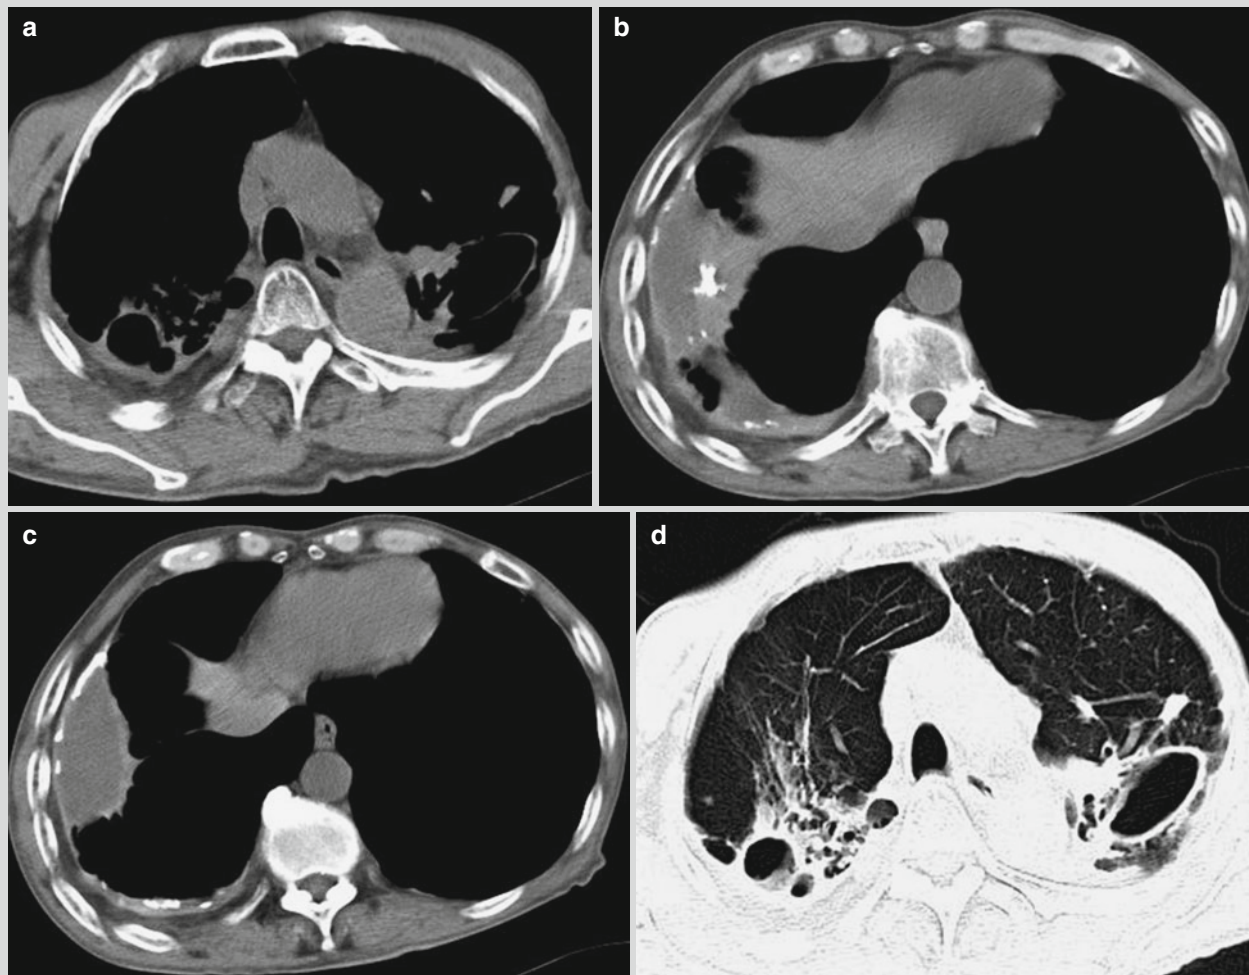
Tuberculous exudative pleuritis (encapsulated pleural effusion), pleural thickening, calcification, and cavity. (a–d) CT scanning demonstrates encapsulated pleural effusion, pleural thickening, calcification, and multiple cavities at both lungs
